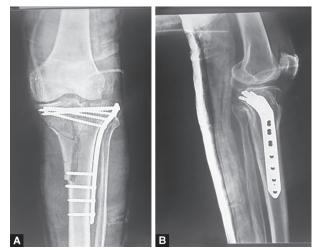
Postop X-ray of proximal tibia fracture treated with ORIF with plate osteosynthesis
